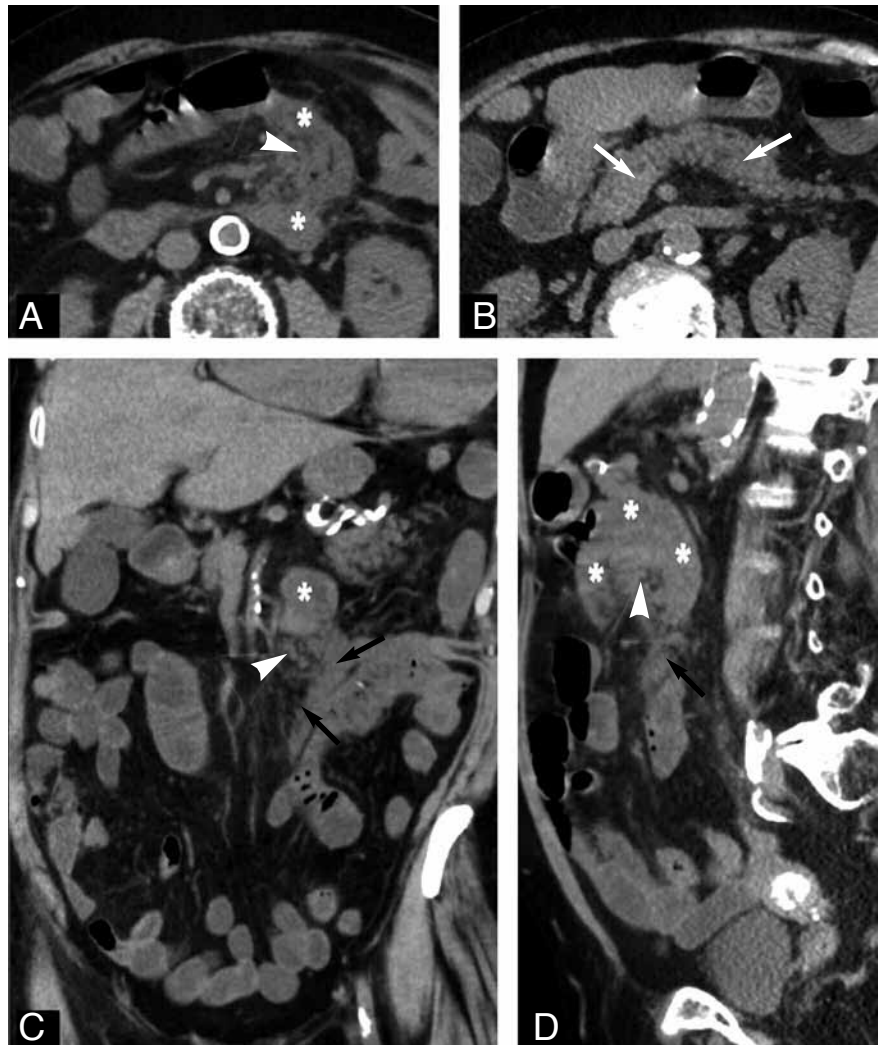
Unenhanced abdominal CT. Axial (A,B), coronal (C) and sagittal (D) views reveal an inflammatory round mass (white arrowhead) adjacent to the duodenojejunal flexure (asterisks), associated with focal bowel wall thickening, peripheral mesenteric fat infiltration and descending fluid collection along the proximal jejunum (black arrows). Pancreatic tissular lobules and fatty interstitium are well perceptible (white arrowhead), similar to normal pancreas (white arrows).
